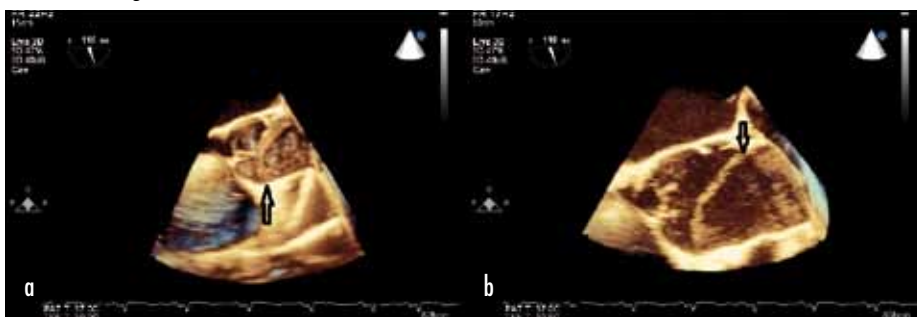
Three-dimensional transoesophageal echocardiogram images (*a* and *b*) showing dissection flap (indicated by arrow) above the aortic valve.
